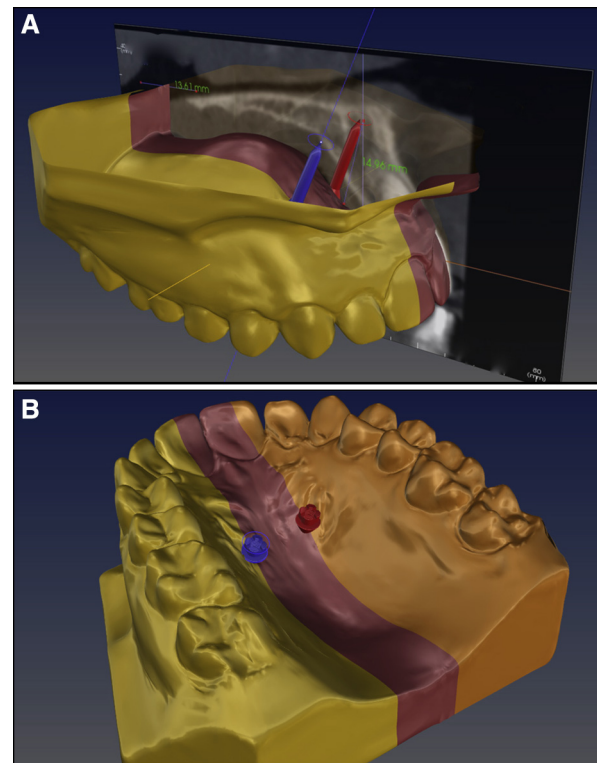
A, Sagittal plane of CBCT scan, showing miniscrews passing through ideal insertion point; B, stereolithographic model with ideal miniscrew insertion sites.
